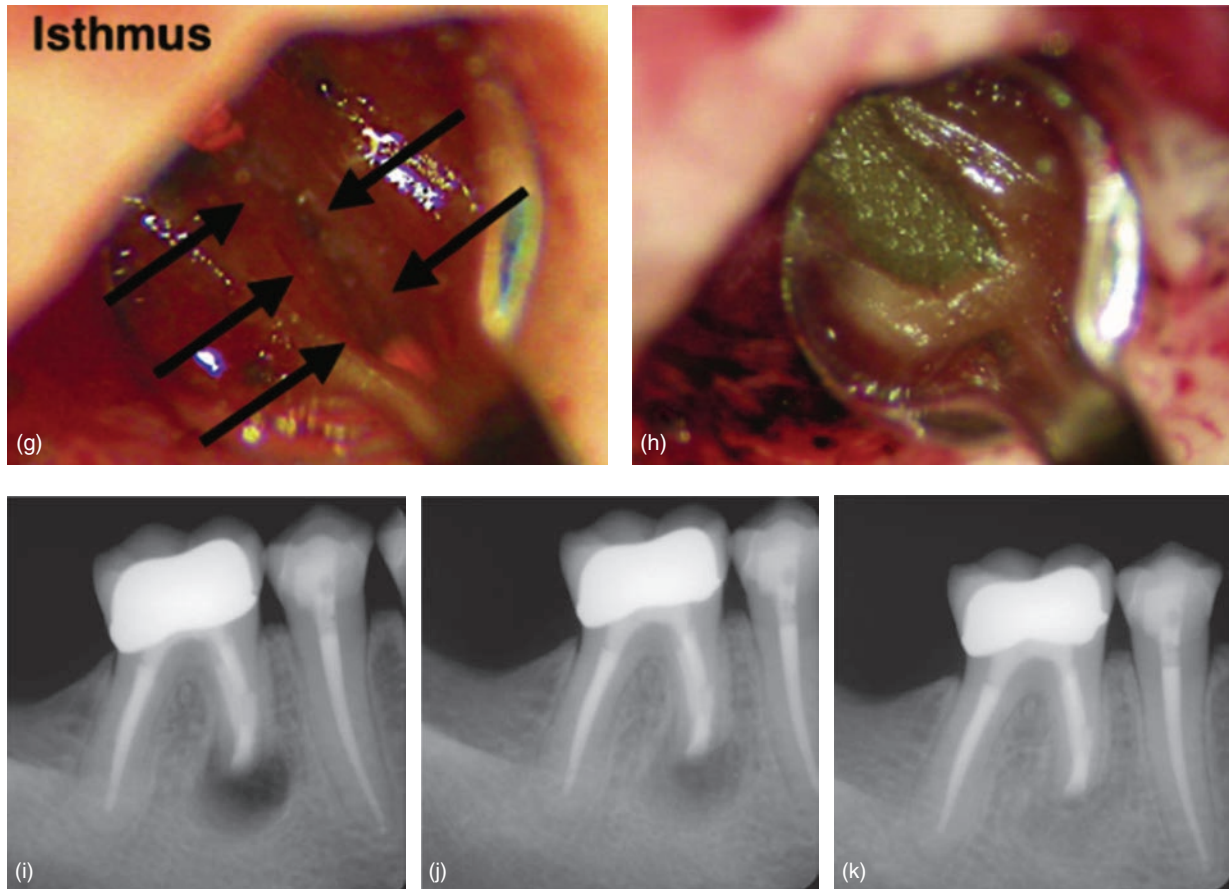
(Continued) (g) Inspection after 3-mm root resection of the mesial root revealed a long type V isthmus (black arrows) (magnification, $\times 16$); (h) root end filling with MTA (magnification, $\times 16$); (i) postoperative radiograph; (j) 6 month recall radiograph; (k) 1 year recall radiograph showing complete healing of the lesion. (Case courtesy of Dr Helmut Walsh.)
